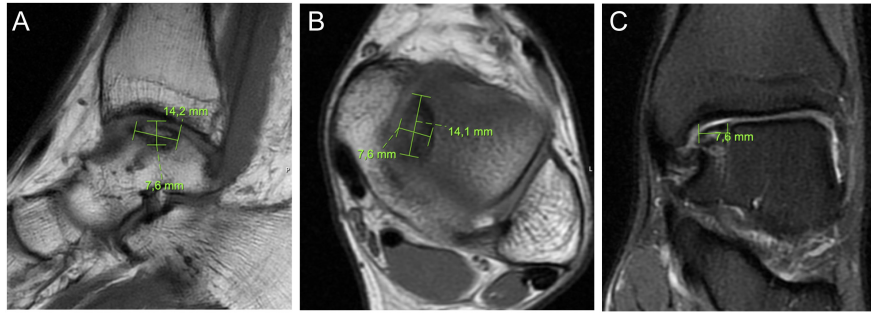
A-C: Measurement of the talus OCD area using magnetic resonance imaging. Sagittal (A), axial (B), and coronal (C) T1- and T2-weighted MR images show the measurement method of the OCD defect area.
